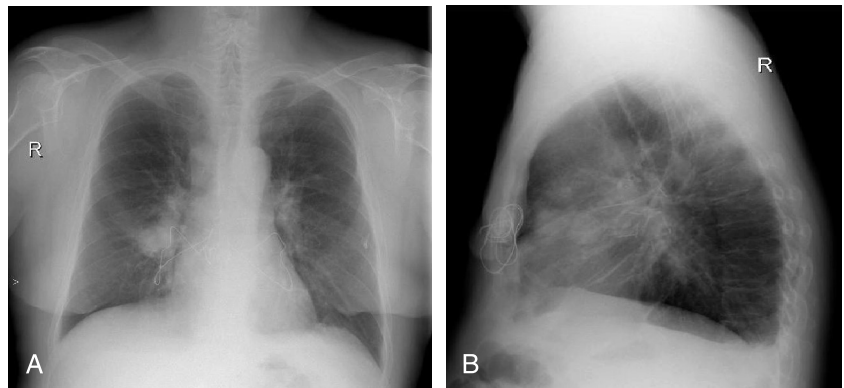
A and B, Chest radiograph showing right middle lobe mass, right paratracheal lymphadenopathy, and bilateral hilar lymphadenopathy.
